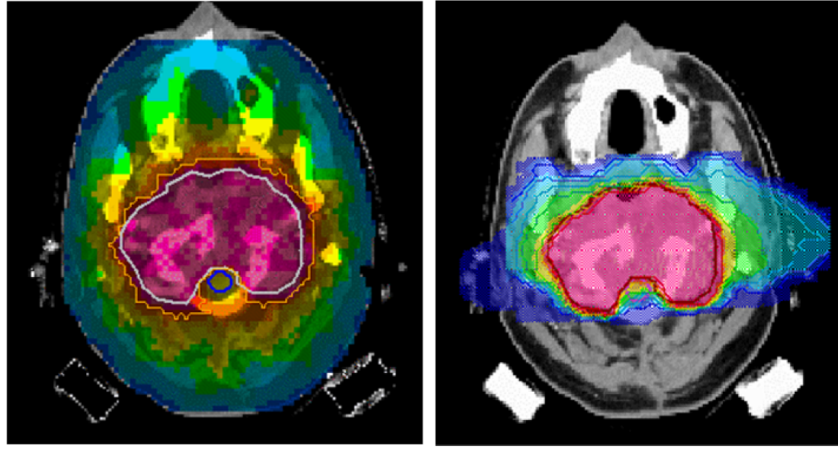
Comparison of treatment plans with 9 fields of X-rays (IMRT – left picture) and with 2 fields of carbon ion (IMPT – right picture). In both cases the dose coverage of the target volume is good but for carbon ions the dose to the normal tissue is much smaller. Figure from (Amaldi and Kraft, 2008).
